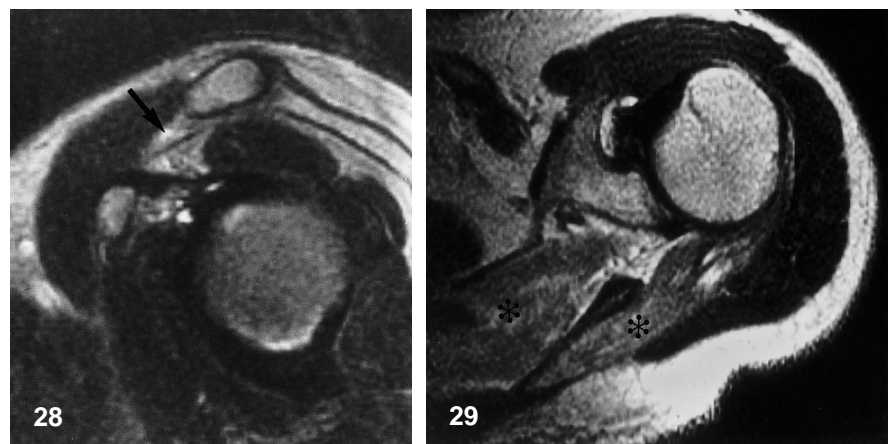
Suprascapular nerve entrapment. Axial T2-weighted MR image (SE 1800/80) showing atrophy and/or edema of the supraspinatus and infraspinatus muscles (*asterisks*). This pattern is seen with abnormalities at the level of the notch including compression by the adjacent soft tissues or scapula, or stretching of the nerve itself. At surgery, the superior transverse scapular ligament was found to be thickened, apparently from a prior injury
